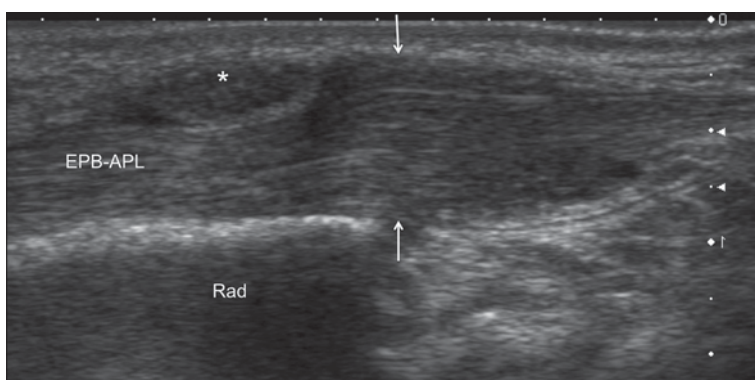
Longitudinal scan on the radial side of the wrist of patient with de Quervain's disease. Thickening of the retinaculum (*) causing entrapment of the tendons. During passive abduction of the thumb, ultrasound revealed crowding of the tendons before the retinaculum (*arrows*). The patient was not able to actively abduct the thumb because of tight stenosis of the first extensor's compartment. *EPB-APL* extensor pollicis brevis and abductor pollicis longus tendons, *Rad* radius
